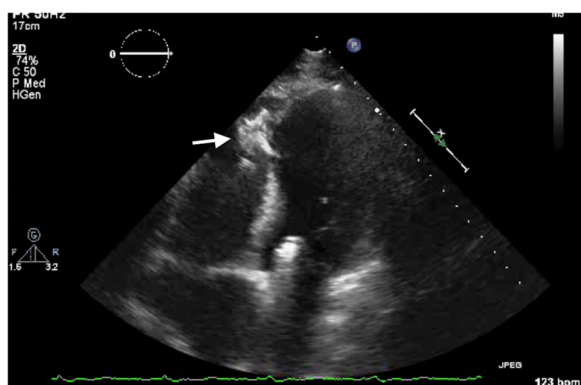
Transthoracic echocardiogram showing successfully repaired ventricular septal rupture with an Amplatzer device (arrow).
